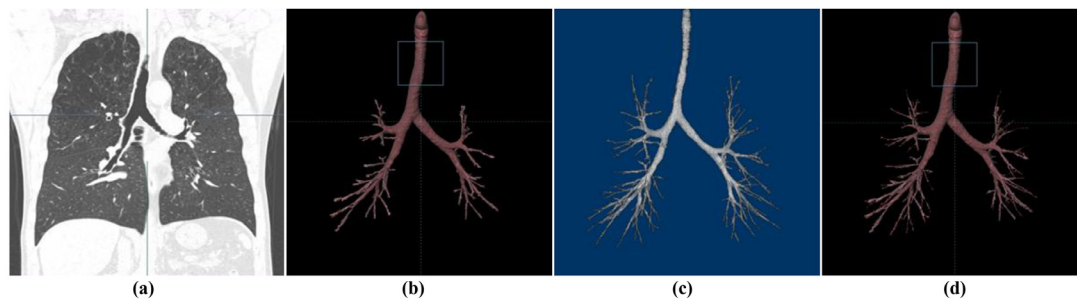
Optimized deep-airway segmentation. (a) A thoracic CT scan. (b) Initial airway. (c) Result of 2.5D CNN. (d) Result of manual segmentation.
